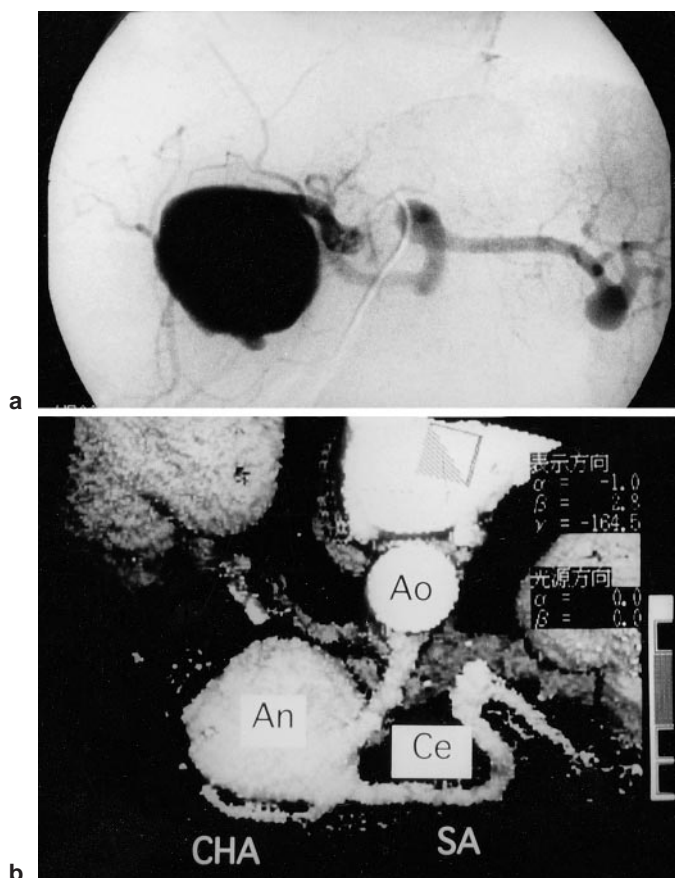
a Digital subtraction angiography revealed a spindle-shaped celiac artery aneurysm associated with a splenic artery aneurysm (case 1). b Three-dimensional computed tomographic (CT) angiography revealed that the common hepatic and splenic arteries originated from the distal end of the celiac artery aneurysm (case 1). *Ao*, aorta; *CHA*, common hepatic artery; *SA*, splenic artery; *An*, aneurysm; *Ce*, celiac artery
